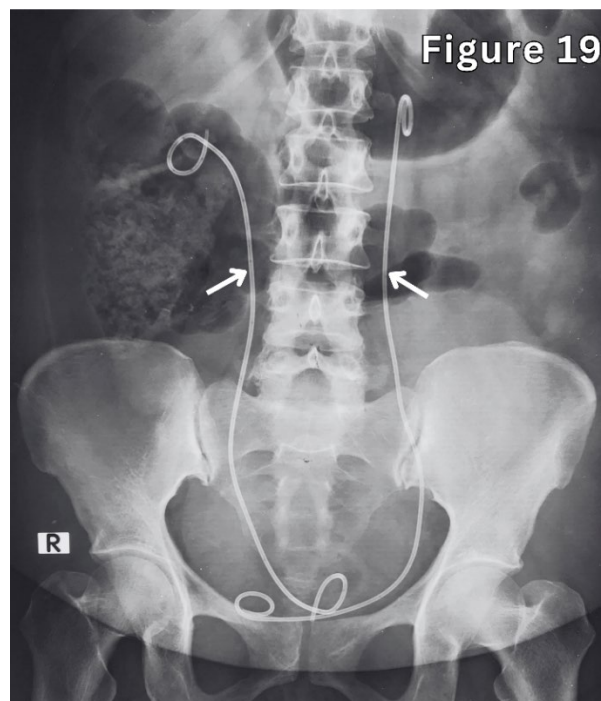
A 39-year-old male with bilateral urolithiasis. Abdominal X-ray shows bilateral ureteric stents in situ.
